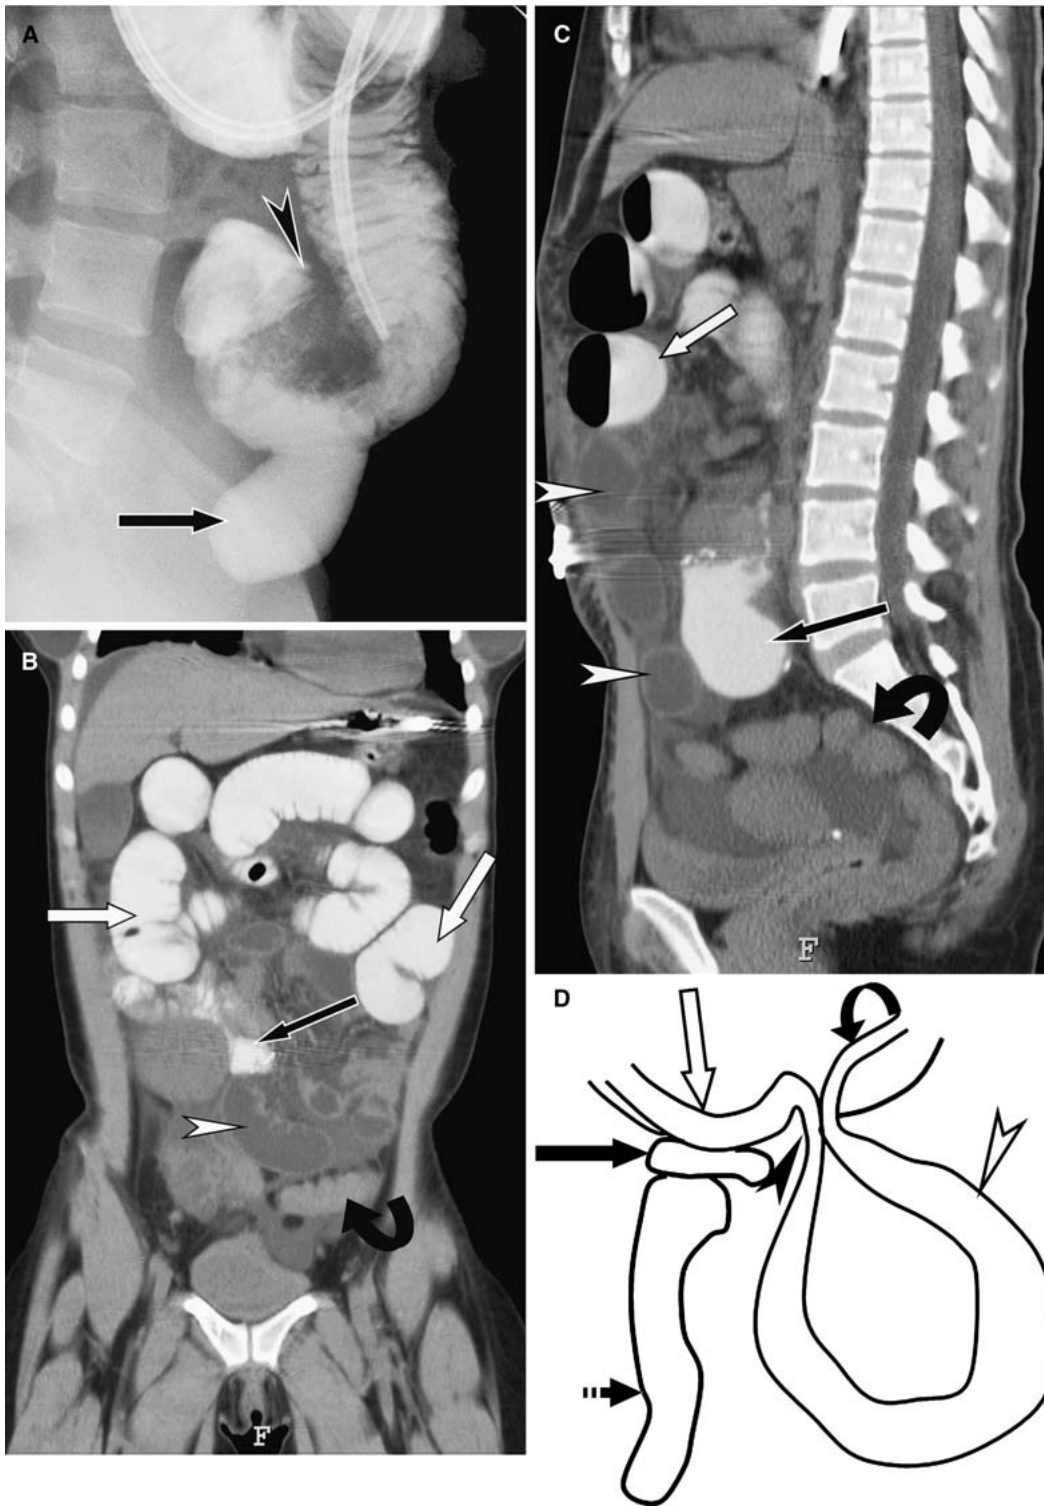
A Fluoroscopic part of CT enteroclysis in a 29-year-old female shows a beaked end at the site of small bowel obstruction (*black arrowhead*). The donor duodenum (*black arrow*) is attached to the jejunum proximal to obstruction. Reformats in coronal (B) and sagittal (C) planes of isotropically acquired CT enteroclysis show a contrast-filled, distended, proximal jejunum (*white arrows*). Note the more distal distended bowel loops (*white arrowheads*) in radial configuration that is not opacified with oral contrast. Pelvic small
